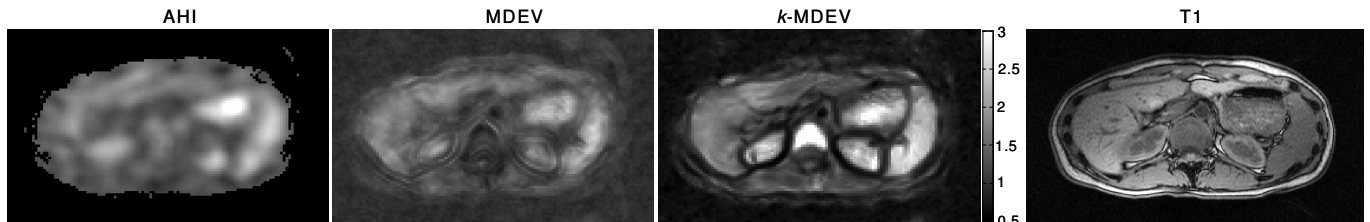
Shear wave speed-maps obtained by algebraic Helmholtz inversion (AHI), MDEV-inversion, and k -MDEV-inversion compared to an anatomical high-resolution T1-weighted MRI scan of same slice position.
